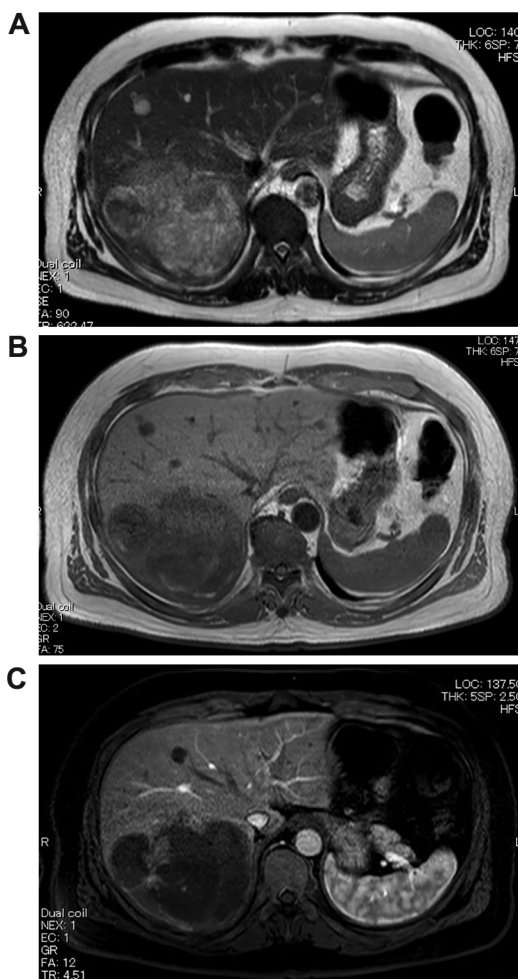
Magnetic resonance imaging demonstrated a liver mass with cystic and irregular solid components measuring 11.5 × 9.0 cm. T1- and T2-weighted imaging showed a hypointense mass with partial hyperintensity and a nonuniform hyperintense mass, respectively (A, B). Dynamic contrast enhancement revealed a hypointense mass with a hyperintense area around the tumor (C).
